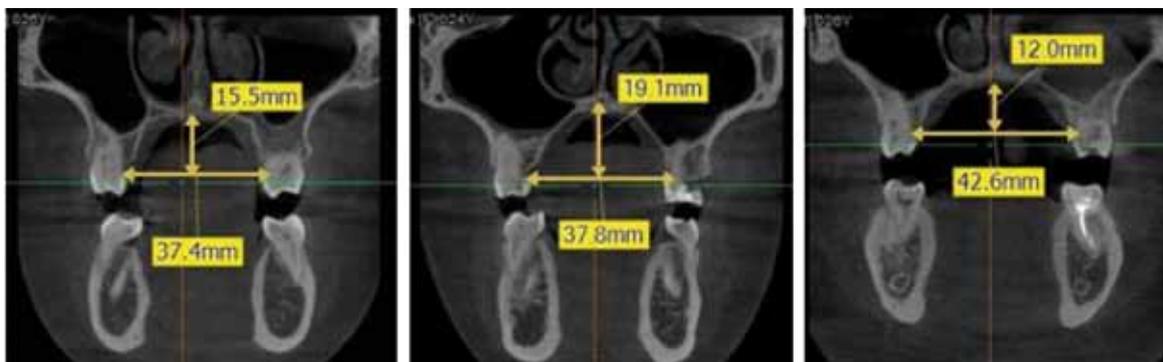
CBCT of patients with mesognathic (a), dolichognathic (b) and brachygnathic (c) dental arches
